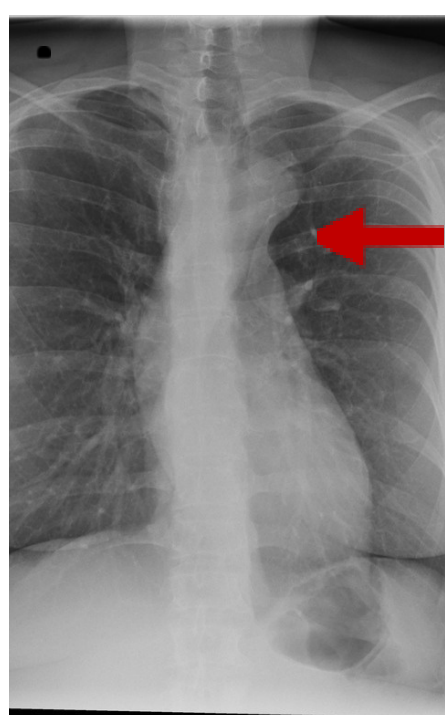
PA Chest X-Ray showing Aortic root dilatation
